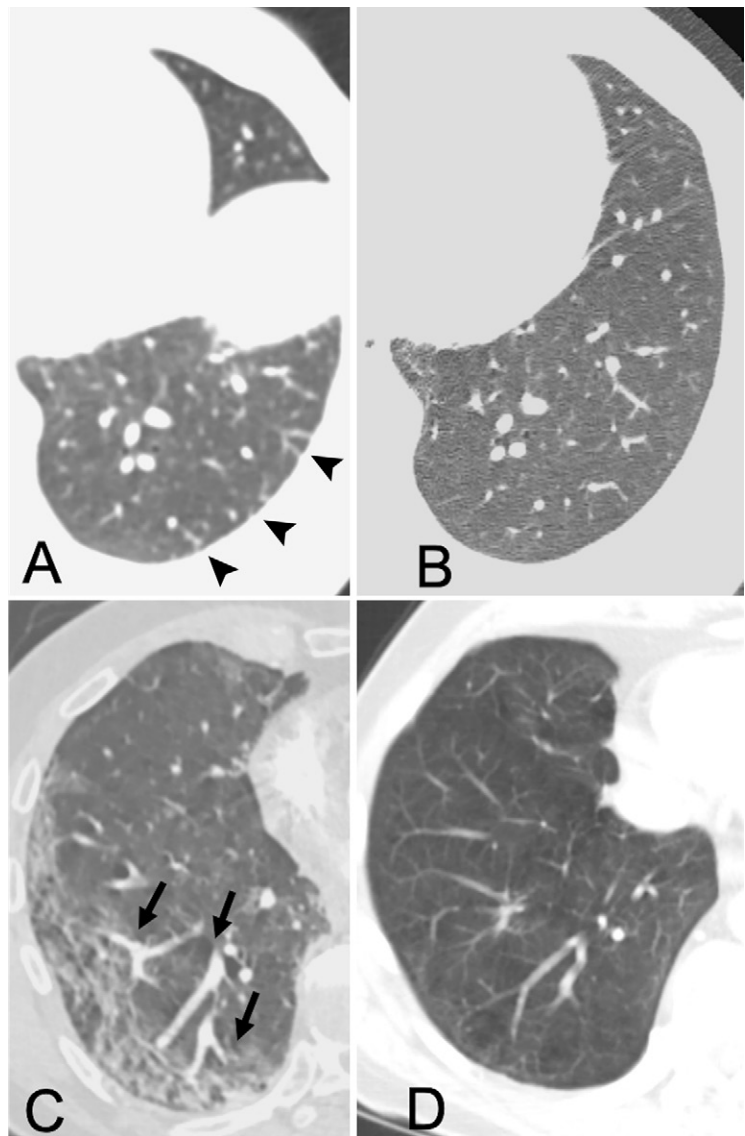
A, B, Images in a 47-year-old woman with a history of metastatic breast cancer who initially presented with nausea, vomiting, and low-grade fever and tested positive for coronavirus disease 2019 (COVID-19) infection. Patient underwent CT pulmonary angiography (CT-PE) on day 4 of admission for acute intermittent tachycardia, lethargy, and new oxygen requirement. A, Axial CT image with lung windows through the left lower lobe at time of presentation shows abnormally dilated distal subsegmental vessels in the subpleural lung touching the pleural surface (arrowheads). B, Image at the same level of CT in the same patient 11 days prior shows normal vessel sizes and appearances, with a normal appearance of the subpleural lung. C, D, Images in a 64-year-old man who presented with acute onset of fatigue, headache, cough, fever, and shortness of breath and tested positive for COVID-19. On day 12 of admission, patient developed increasing oxygen requirement and CT-PE was performed. C, Axial CT image with lung windows through the right lower lung shows peripheral regional ground-glass opacity in the right lower lobe, with dilated segmental and subsegmental vessels supplying the region of opacified lung (arrows) and smaller diameters of vessels in unaffected lung. D, Image at the same level of a CT scan in the same patient approximately 3 months prior shows normal appearance of vessels.
